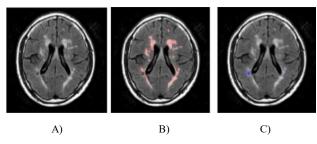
An example of subject from WMH Segmentation Challenge of MICCAI 2017: A) T2-FLAIR image, B) WMH ROI overlap on T2-FLAIR image, C) other pathological ROI overlap on T2-FLAIR image.
